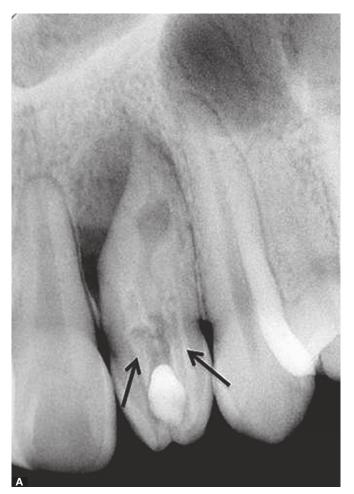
A) Periapical radiograph showing a maxillary right lateral incisor with double *dens invaginatus*. The arrows show the invaginations. B) Follow-up radiograph after 12 months showing periapical healing.
